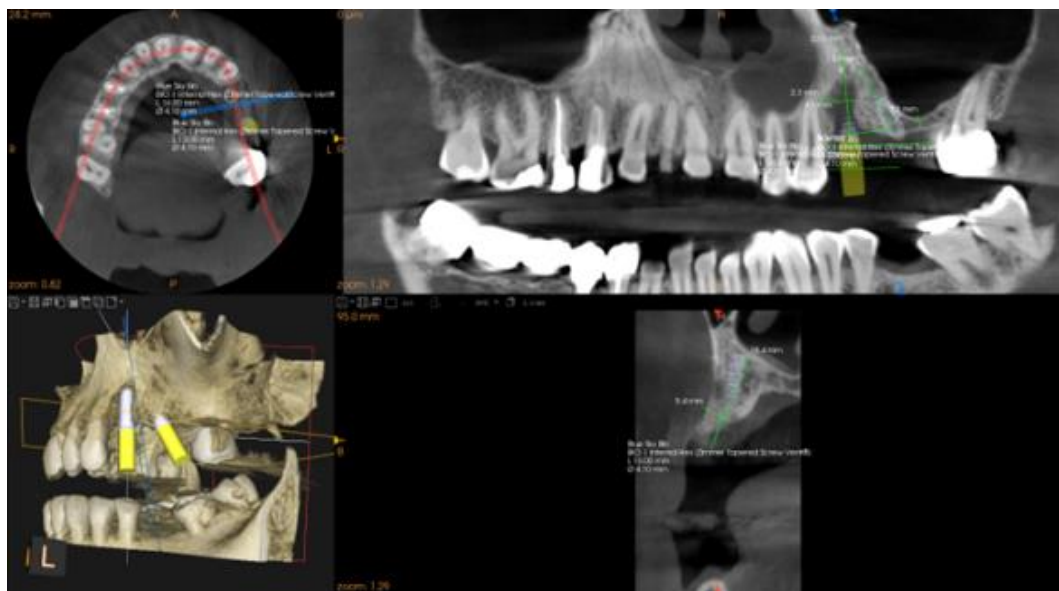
CBCT implant placement planning
